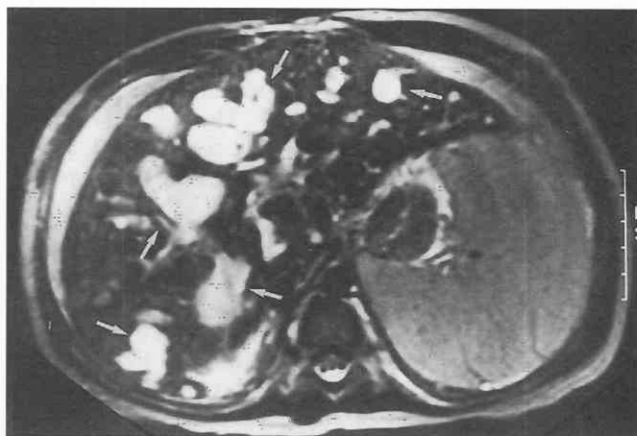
Biliary dilatation related to congenital hepatic fibrosis associated with autosomal recessive polycystic kidney disease. T2-weighted MR image of the liver demonstrates numerous large, high-signal-intensity regions of biliary dilatation (arrows). (Courtesy of Dr. Cynthia K. Rigsby, Children's Memorial Hospital, Chicago.)
